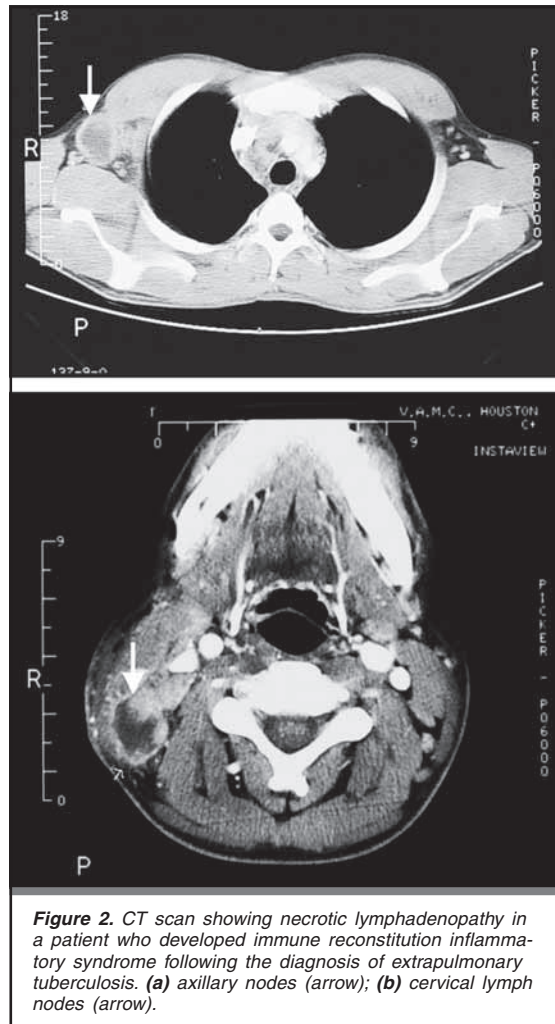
CT scan showing necrotic lymphadenopathy in a patient who developed immune reconstitution inflammatory syndrome following the diagnosis of extrapulmonary tuberculosis. (a) axillary nodes (arrow); (b) cervical lymph nodes (arrow).
